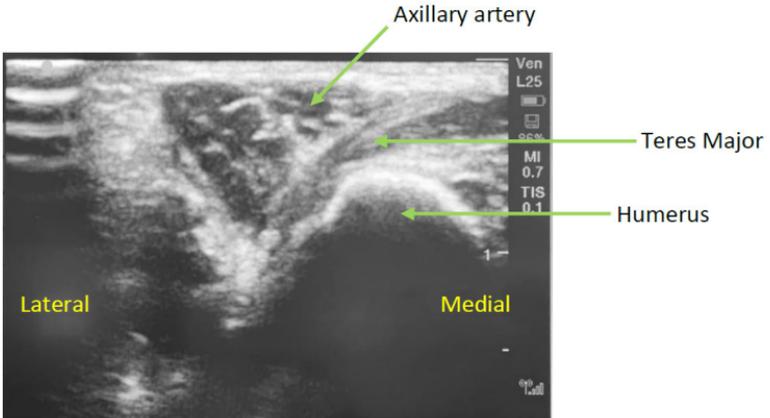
Ultrasound image prior to needle placement.
